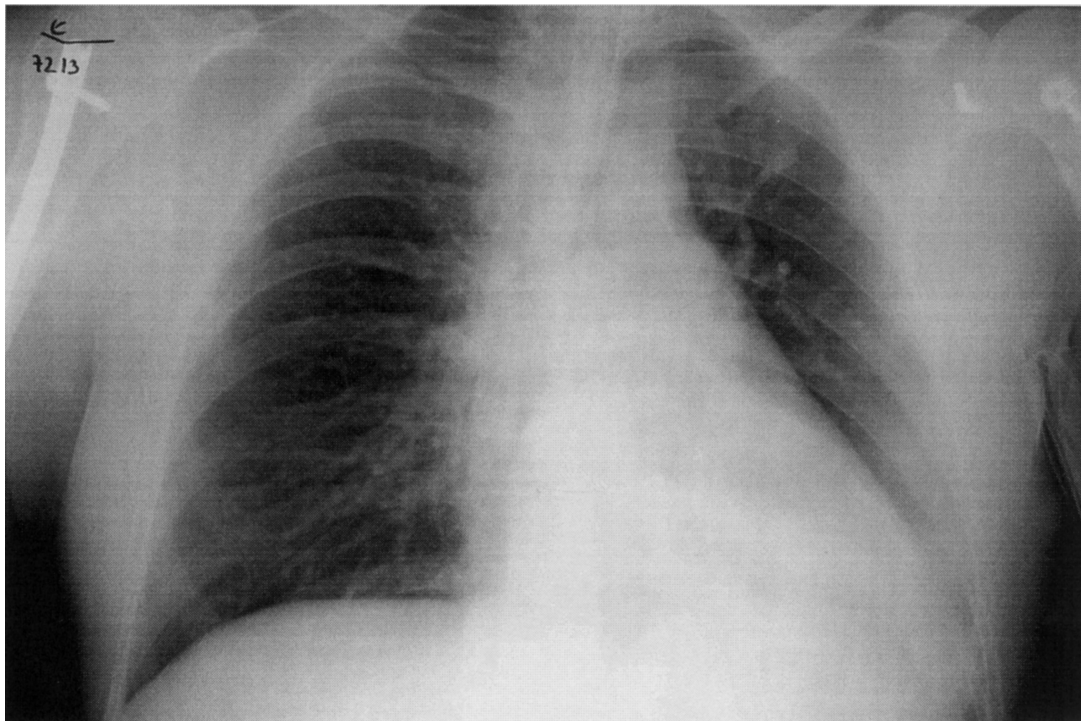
Chest roentgenograph on admission.
